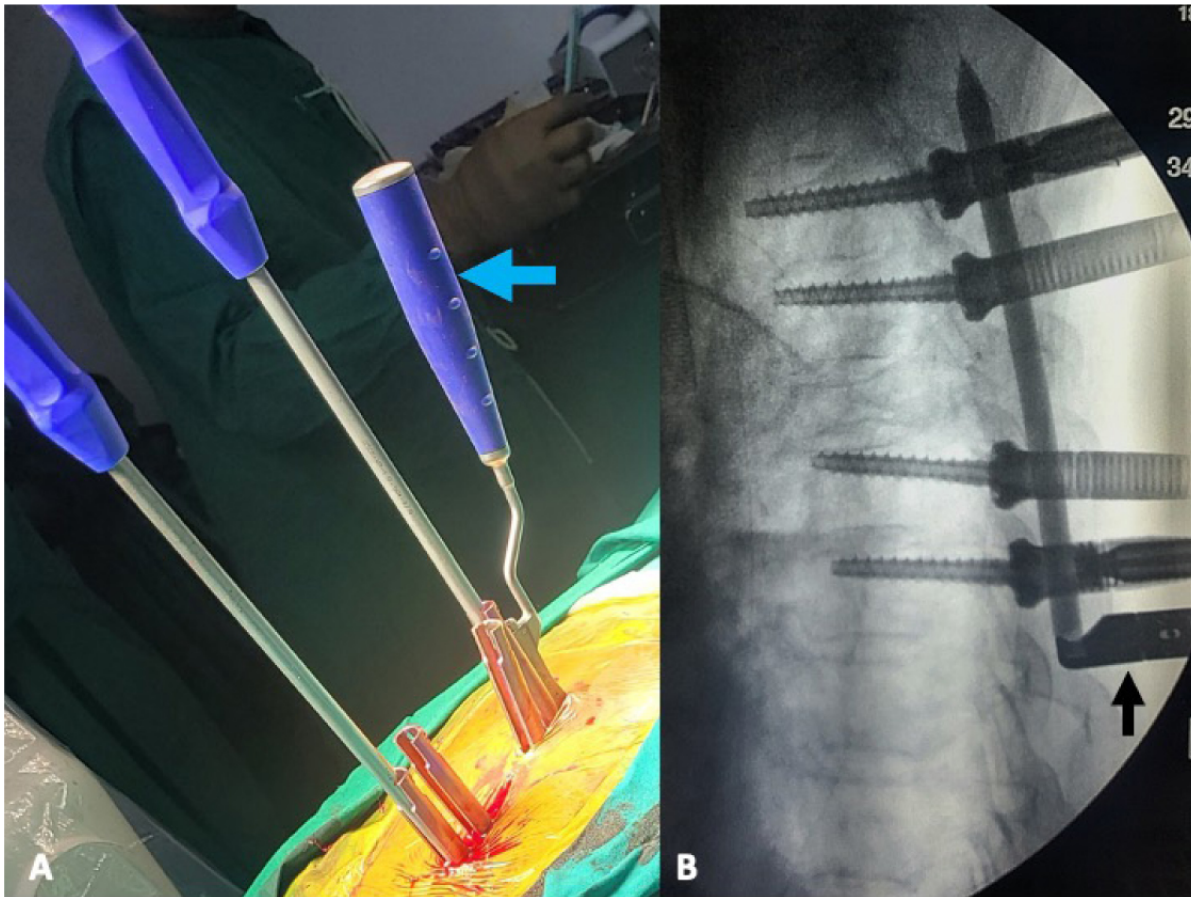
Patient with T5 body collapse secondary to tuberculosis. (A) Clinical photograph showing rod holder (blue arrow) passed along the screw extension tab. (B) Lateral X-ray showing that the rod has been successfully passed subfascially to engage all the screw heads. Black arrow shows the rod holder.
